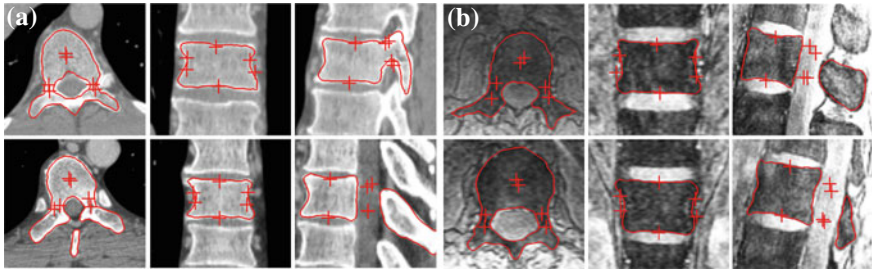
Qualitative assessment of the spine model segmentation in CT a and MR b images for two levels with projected anatomical landmarks
